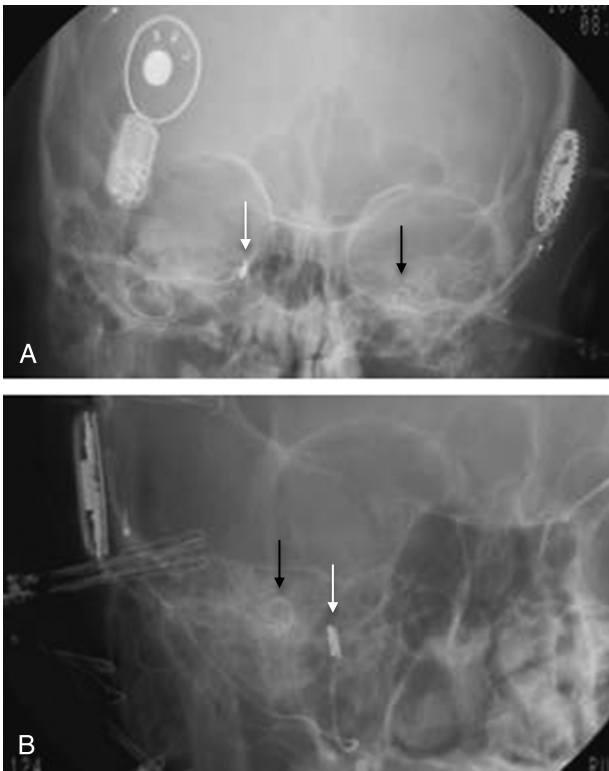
A, X-ray of patient C, showing ABI on the right side (*white arrow*) and CI on the left side (*black arrow*). B, X-ray of patient B, showing ABI (*white arrow*) and CI (*black arrow*) on the right side. ABI, auditory brainstem implant. CI, cochlear implant.
